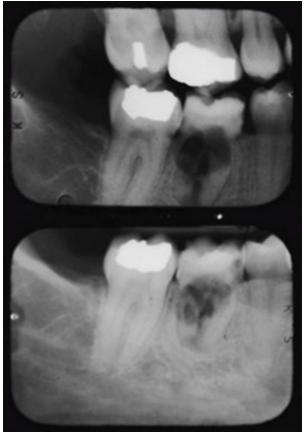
and 66B. Bitewing (A) and periapical (B) radiographs showing internal resorption of mandibular right first molar tooth #30.
